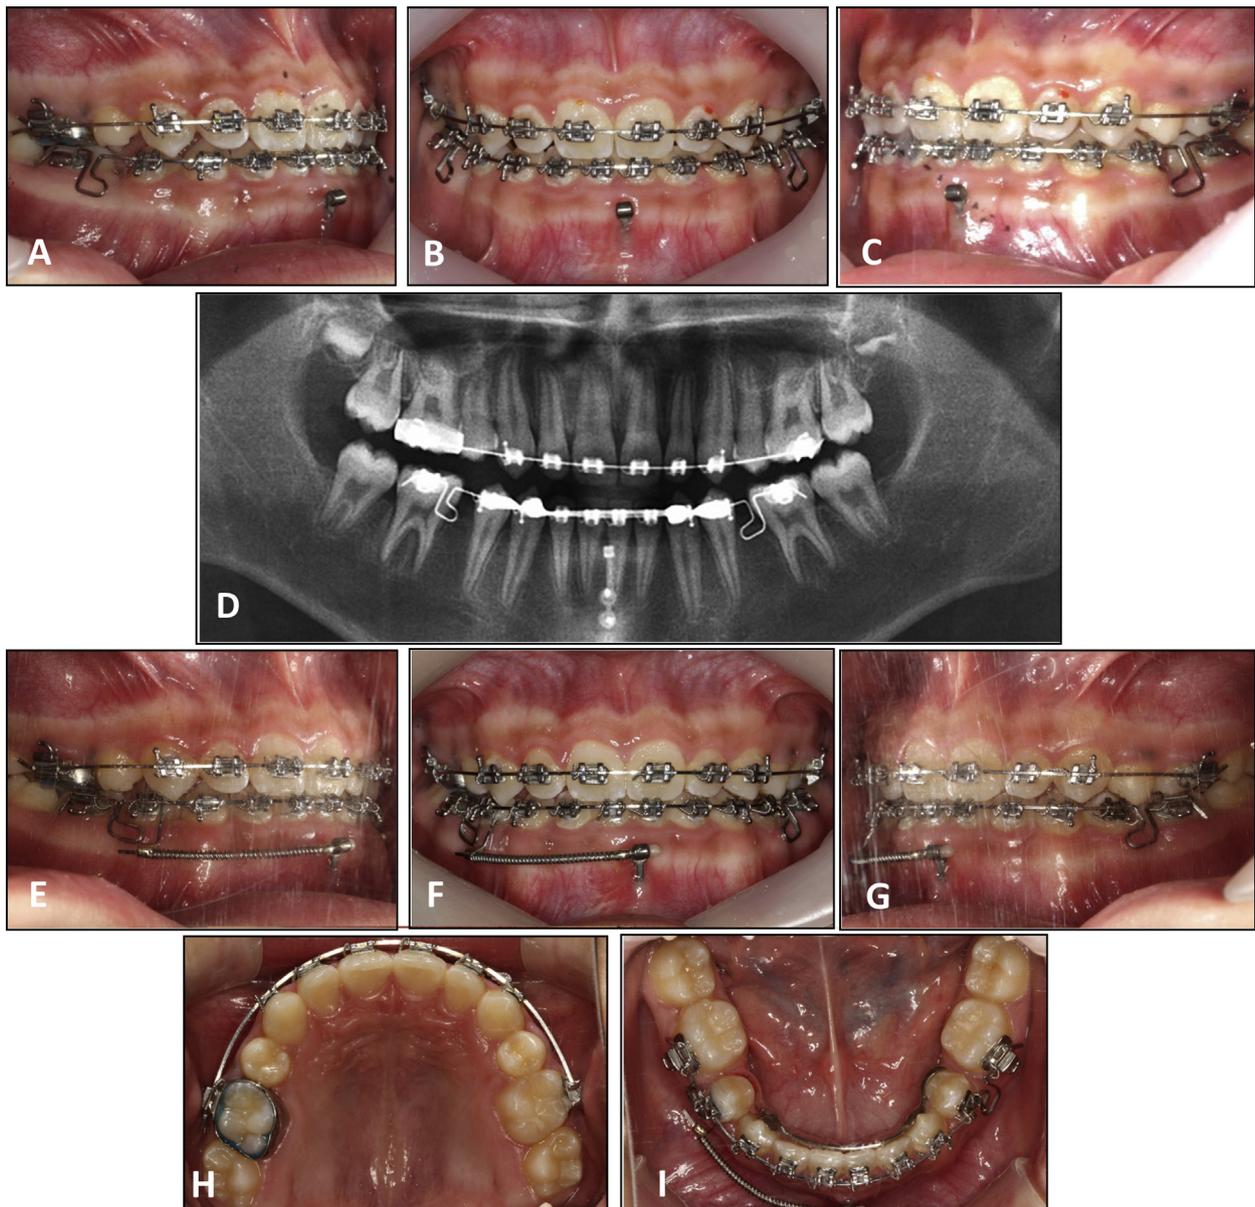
Treatment process: A-C, intraoral view, and D, panoramic radiography during molar protraction. The space of donor teeth was closed by protraction of lower molars. C-tube miniplate was used to prevent lingual tipping of lower anterior teeth after autotransplantation (13 years 3 months of age). E-I, Intraoral view of dental midline correction with the use of C-tube and open coil spring (13 years 6 months of age).
